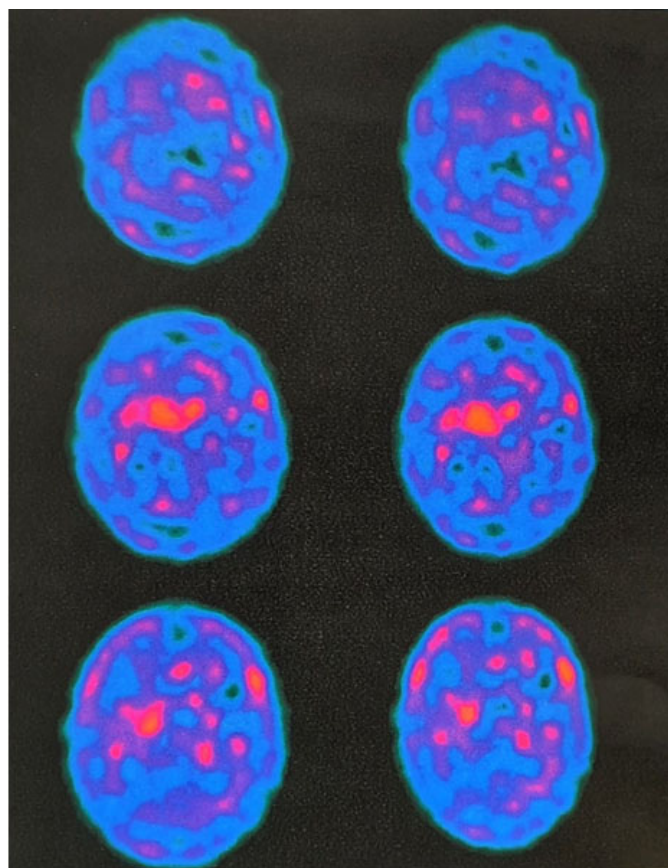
Skull scintigraphy with marked nigrostriatal dopaminergic dysfunction.
